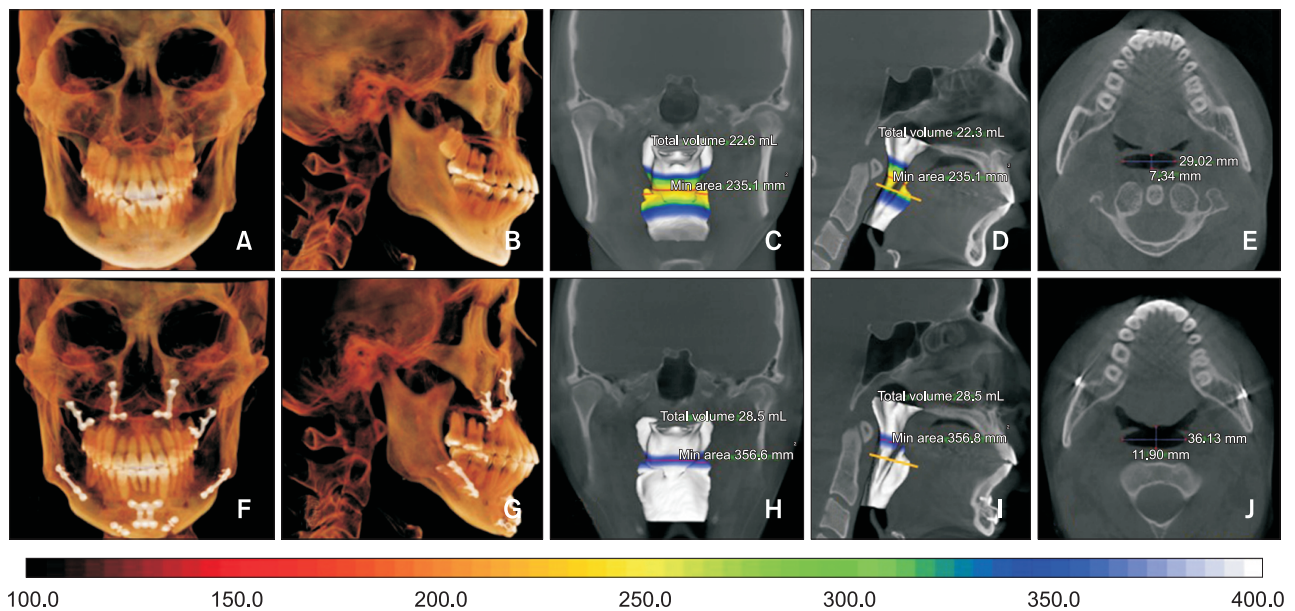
Comparative cone-beam computed tomography images of the craniofacial and pharyngeal airway in three dimensions at pretreatment (A-E) and 1.5 years post-retention (F-J).
